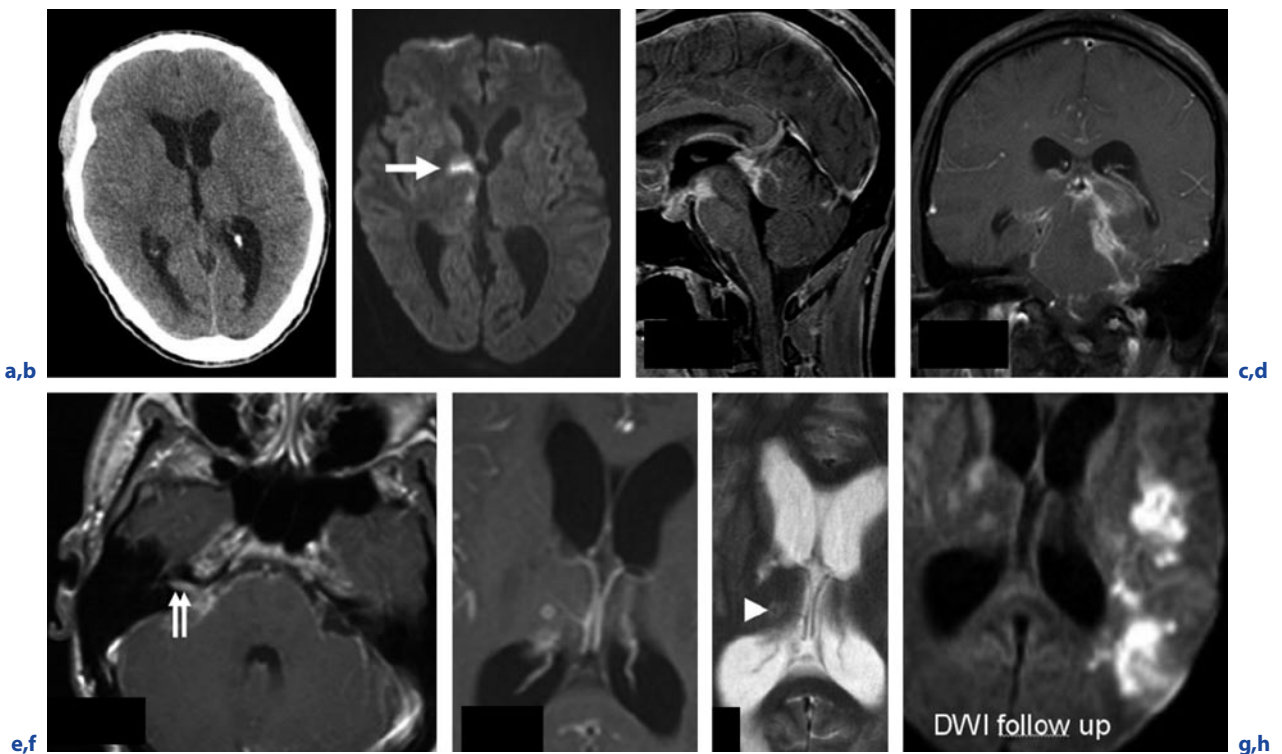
A 24-year-old man who suffered from fever, headache and weight loss for several weeks and came to admission after a seizure. a Non-enhanced CT. b Axial DWI. c Sagittal T1-weighted image after contrast administration. d Coronal T1-weighted image after contrast administration. e,f Axial T1-weighted image after contrast administration. g Axial T2-weighted image. h Axial DWI (follow-up). (a) Enlarged ventricles. On DWI (b) focal hyperintensities are seen at the level of the right thalamus and the basal ganglia (*arrow*) with reduced ADC values, reflecting acute infarcts. Key to the diagnosis is
